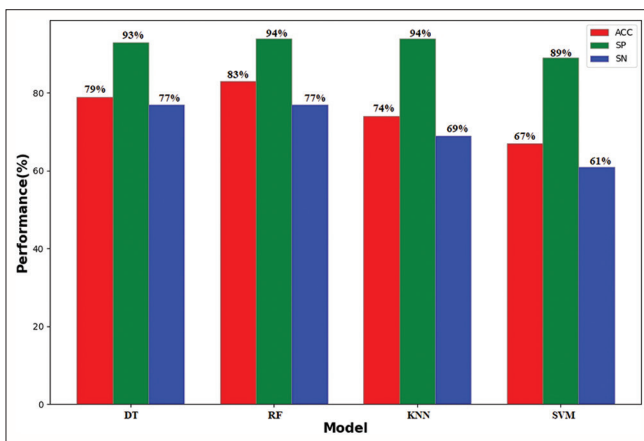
Barplot of the performance of the predictive models for single-photon emission computed tomography-computed tomography features in order of accuracy, specificity, and sensitivity. DT: Decision tree, RF: Random forest, KNN: K-nearest neighbor, SVM: Support vector machine
